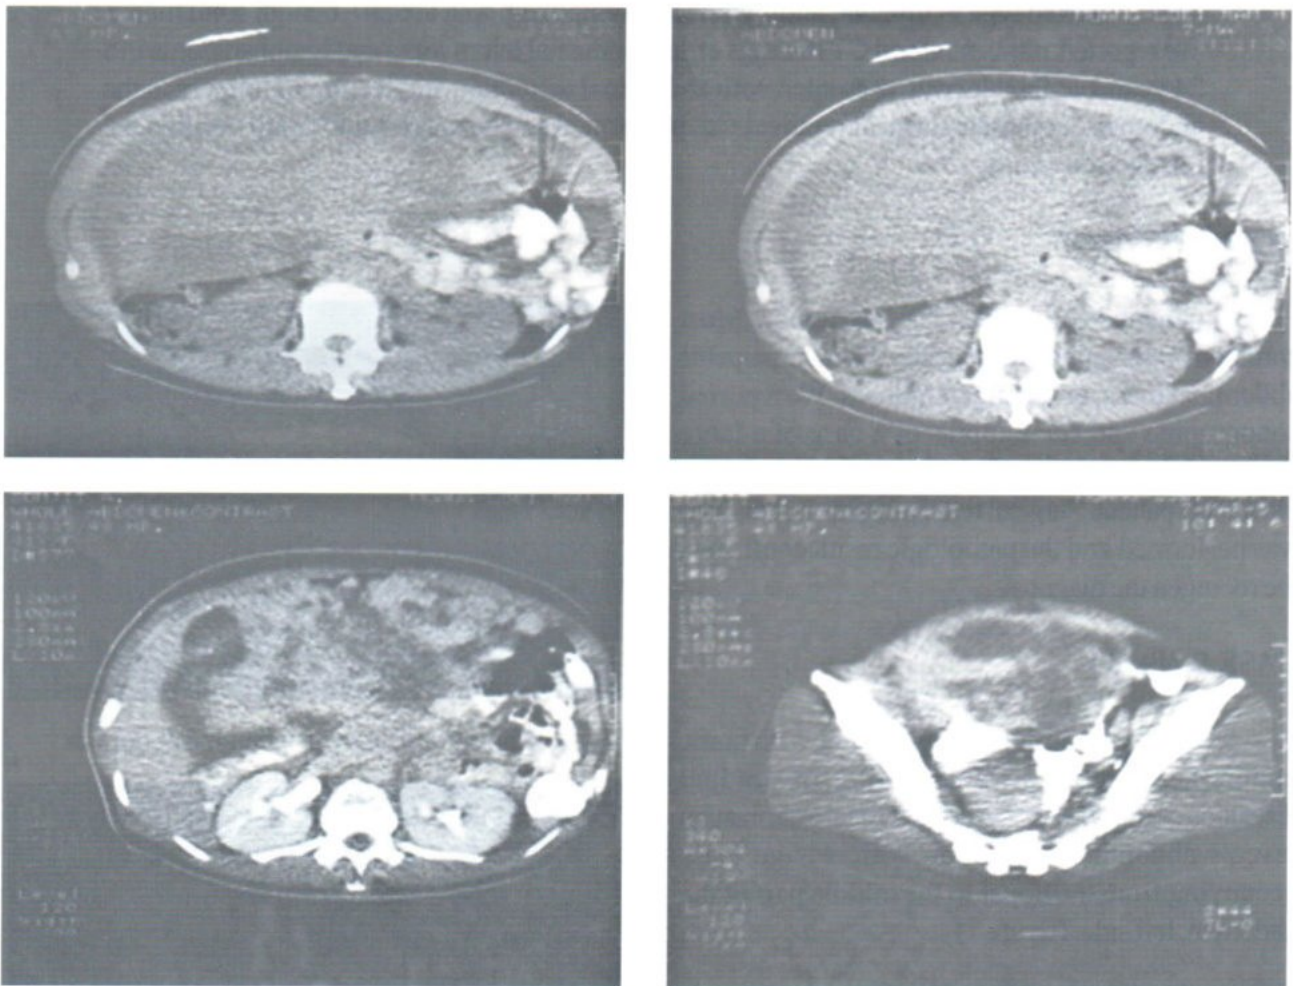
CT scan showed a large, well defined border, inhomogeneous mixed attenuated solid mass with minimally enhancement, not attached to the uterus. Multiple small enhancement tortuous tubular structures and small cystic lesions at the anterior surface of mass, were noted.
